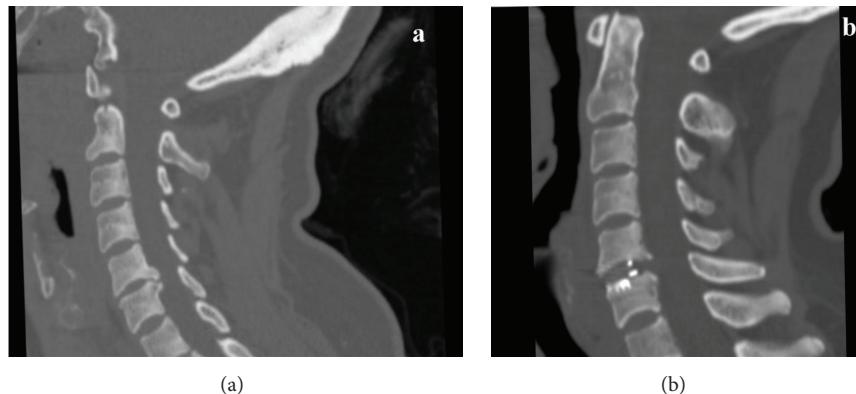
(a) Preoperative and (b) postoperative sagittal CT images of a C5-6 disc herniation with osteophytes.
